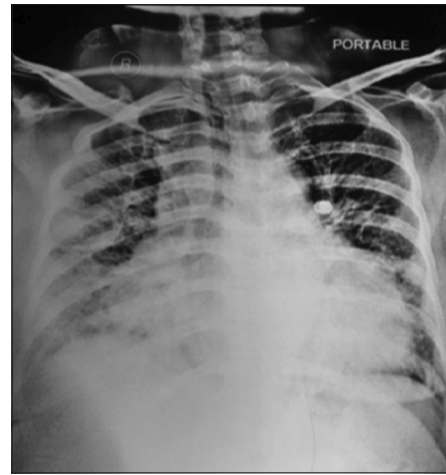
Portable chest X-ray suggestive of acute pulmonary edema
